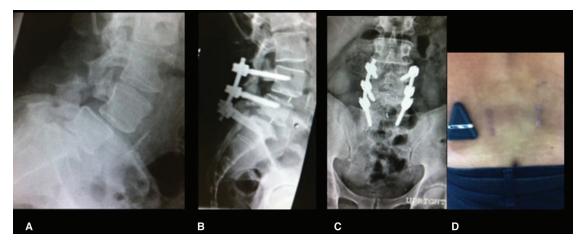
A 46-year-old male presenting with severe debilitating back pain from L4–L5 and L5–S1 grade 1 spondylolisthesis. Preoperative plain radiographs (A), and postoperative lateral (B) and anteroposterior (C) view after 2 level L4–L5 and L5–S1 MITLIF. Postoperative healed incision (D). Patient made an uneventful recovery with resolution of symptoms and return to work. MITLIF indicates minimally invasive transforaminal lumbar interbody fusion.
